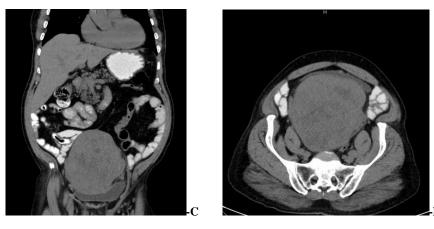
CT revealed a prostatic mass lesion which displeased the bladder inferiorly
